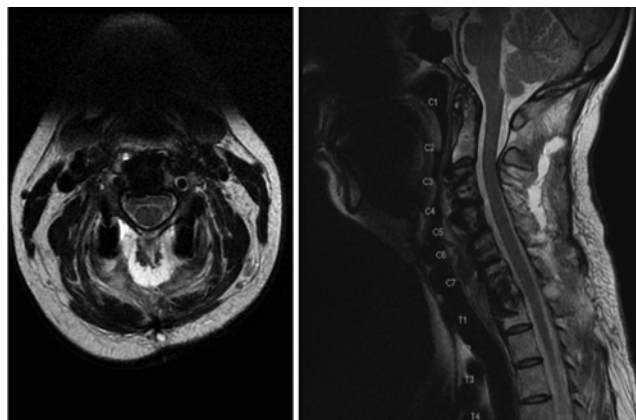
Case 1. Postoperative axial (left) and sagittal (right) T2-weighted MR image of the cervical spine demonstrating a T2 hyperintense fluid collection overlying the C2–6 levels consistent with a seroma.
